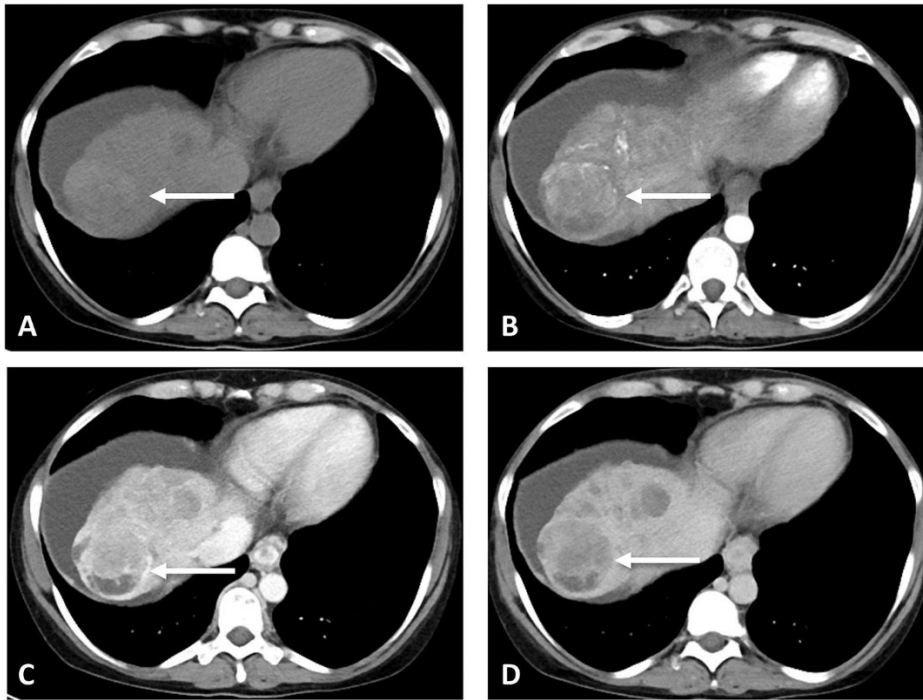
Appearance of masses in different phases of CT images. The masses in the images of four phases, i.e., the (A) NC, (B) ART, (C) PV and (D) DL, show different appearance [7].
